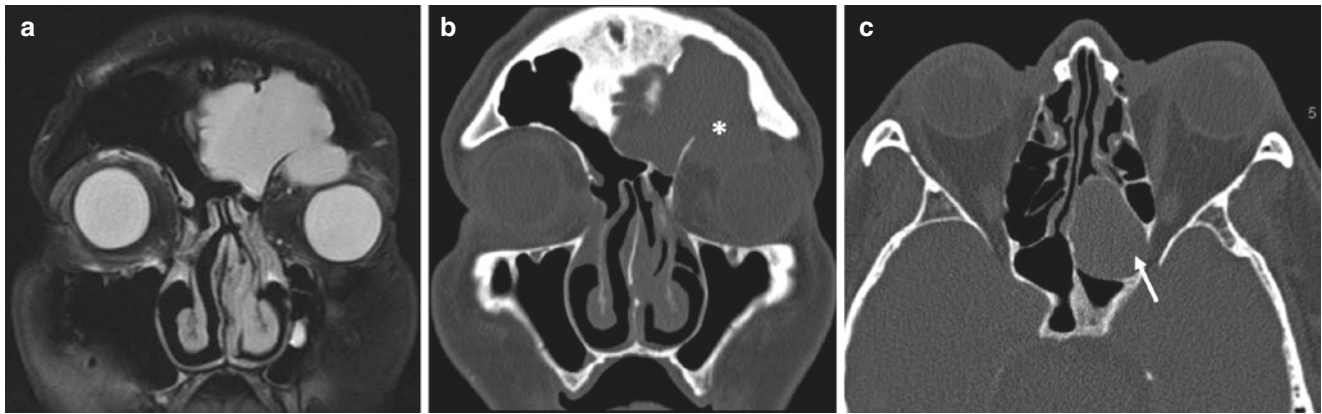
Fronto-ethmoidal sinus mucocoele filling the sinuses on T2w coronal MRI (a) and extending into superior left orbit eroding through the roof of the orbit (*) as shown on coronal bone window CT
